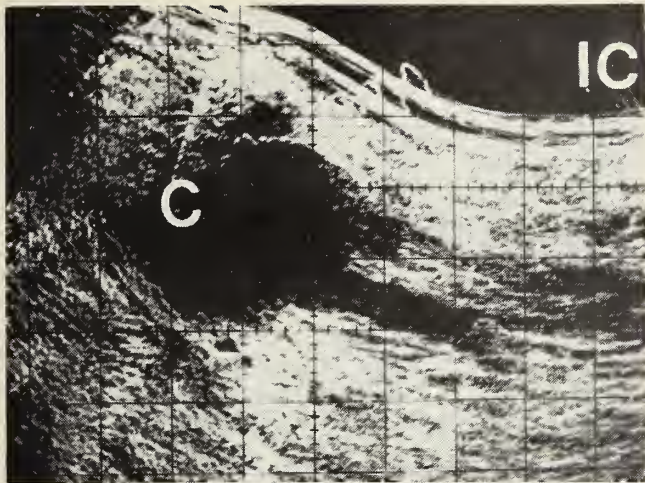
Solitary renal cyst. High gain longitudinal renal ultrasonogram shows an echofree volume (C) in the superior pole of the kidney measuring 5.5 cm in diameter. Iliac crest (IC).
